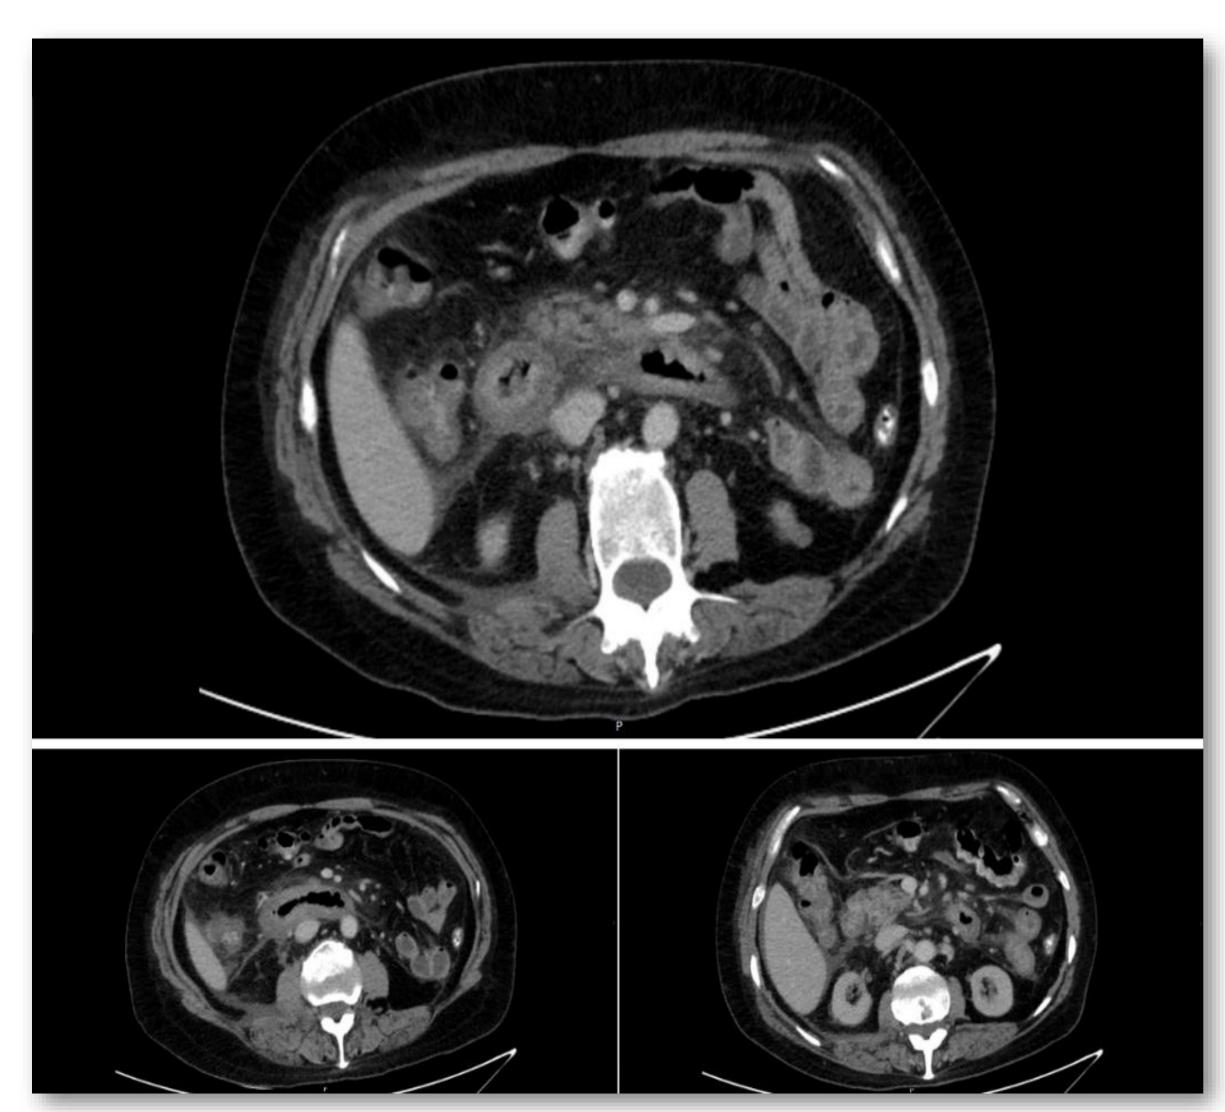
Abdominal-CT revealing marked diffuse parietal thickening of the duodenum with a slightly hypodense appearance. Pancreas shows globosity of the head and uncinate process, associated with weeks after treatment confirmed mucosal healing. marked densification of peripancreatic fat. These imagological findings are suggestive of inflammatory alterations of the pancreatic parenchyma secondary to small bowel disease.
